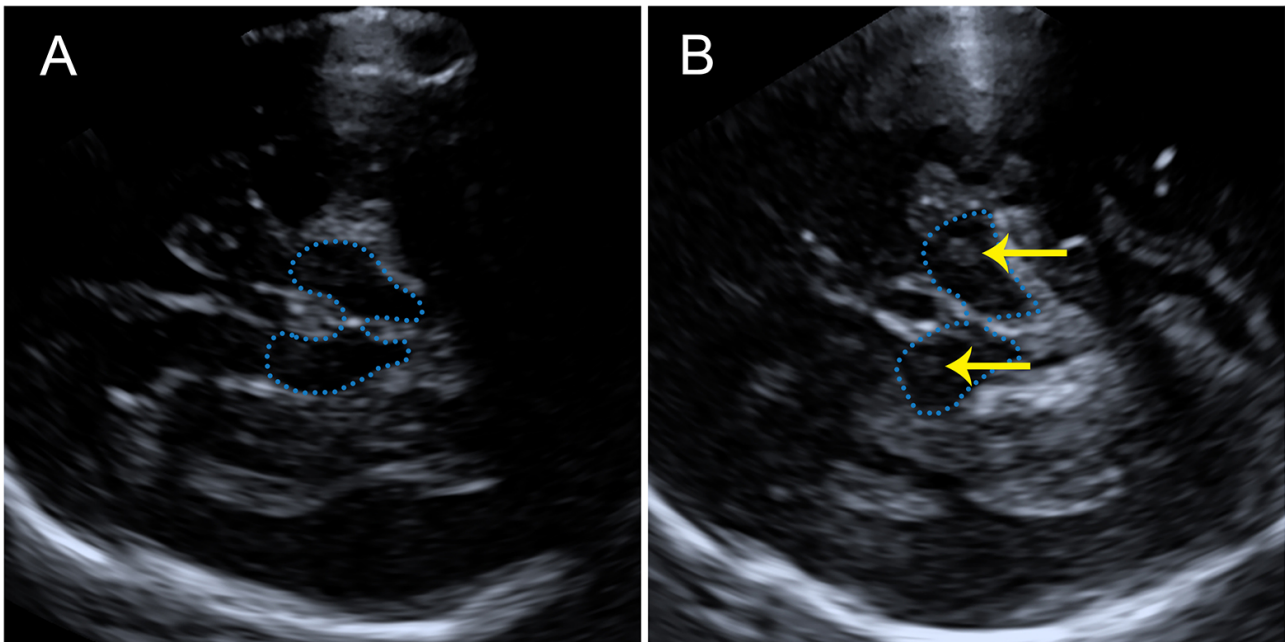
Transcranial ultrasonography showing butterfly-shaped midbrain and internal sonographic features. (A) No significant substantia nigra hyperechogenicity (SNH) is detected within the midbrain. (B) Focal SNH is visualized within the midbrain (yellow arrow). The blue dashed line outlines the midbrain region.
